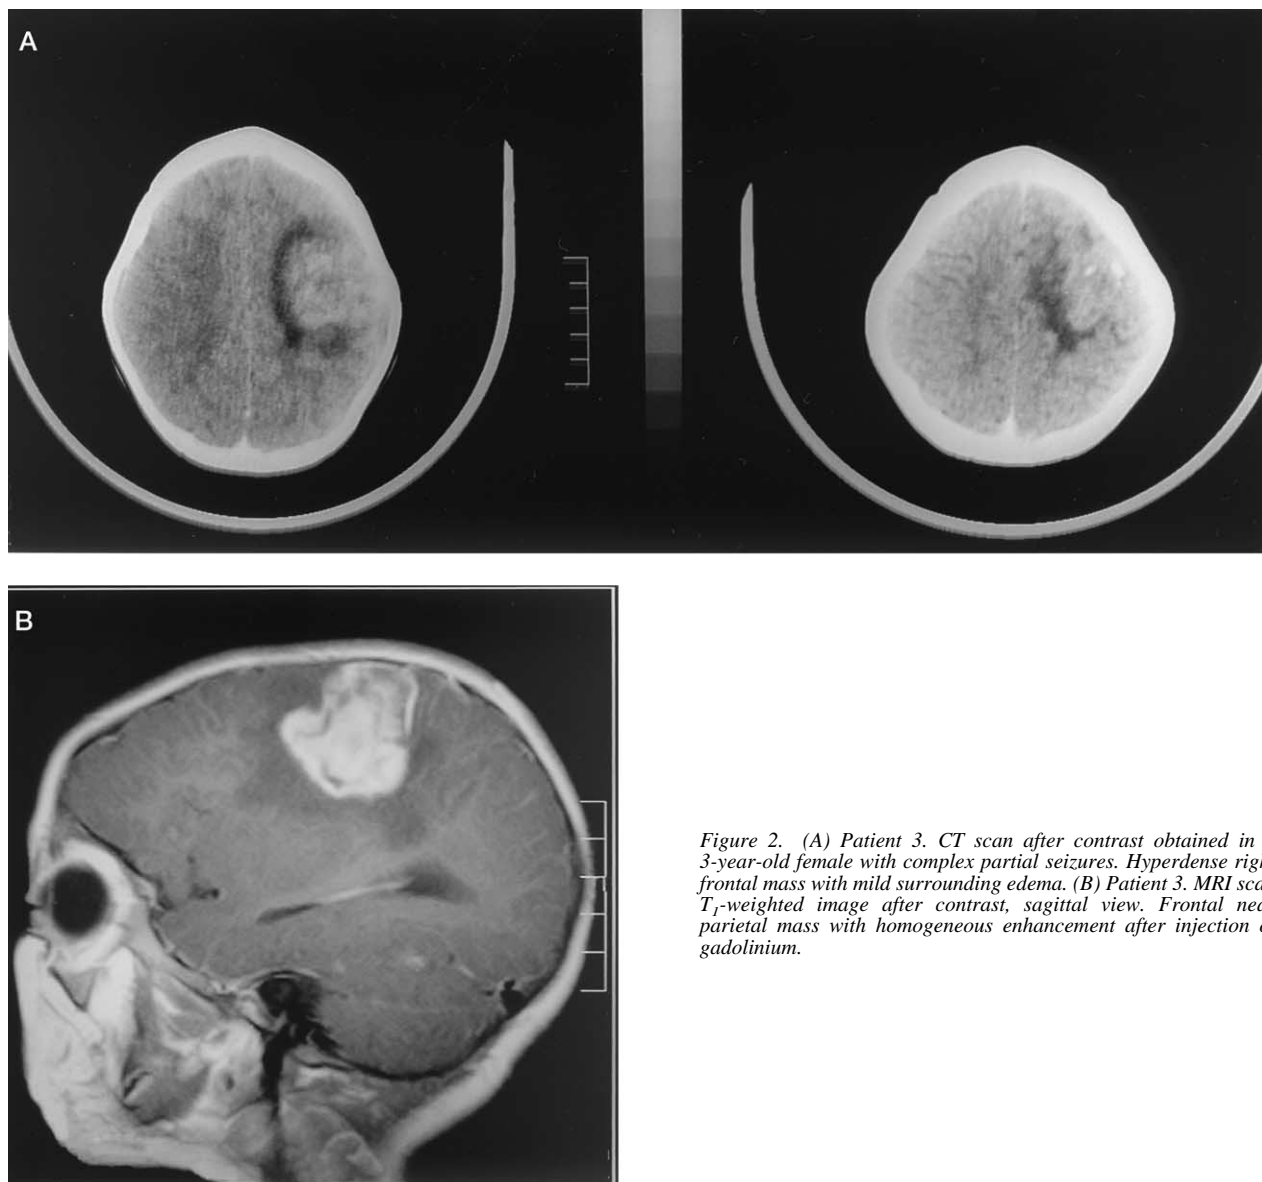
(A) Patient 3. CT scan after contrast obtained in a 3-year-old female with complex partial seizures. Hyperdense right frontal mass with mild surrounding edema. (B) Patient 3. MRI scan T_1 -weighted image after contrast, sagittal view. Frontal near parietal mass with homogeneous enhancement after injection of gadolinium.
